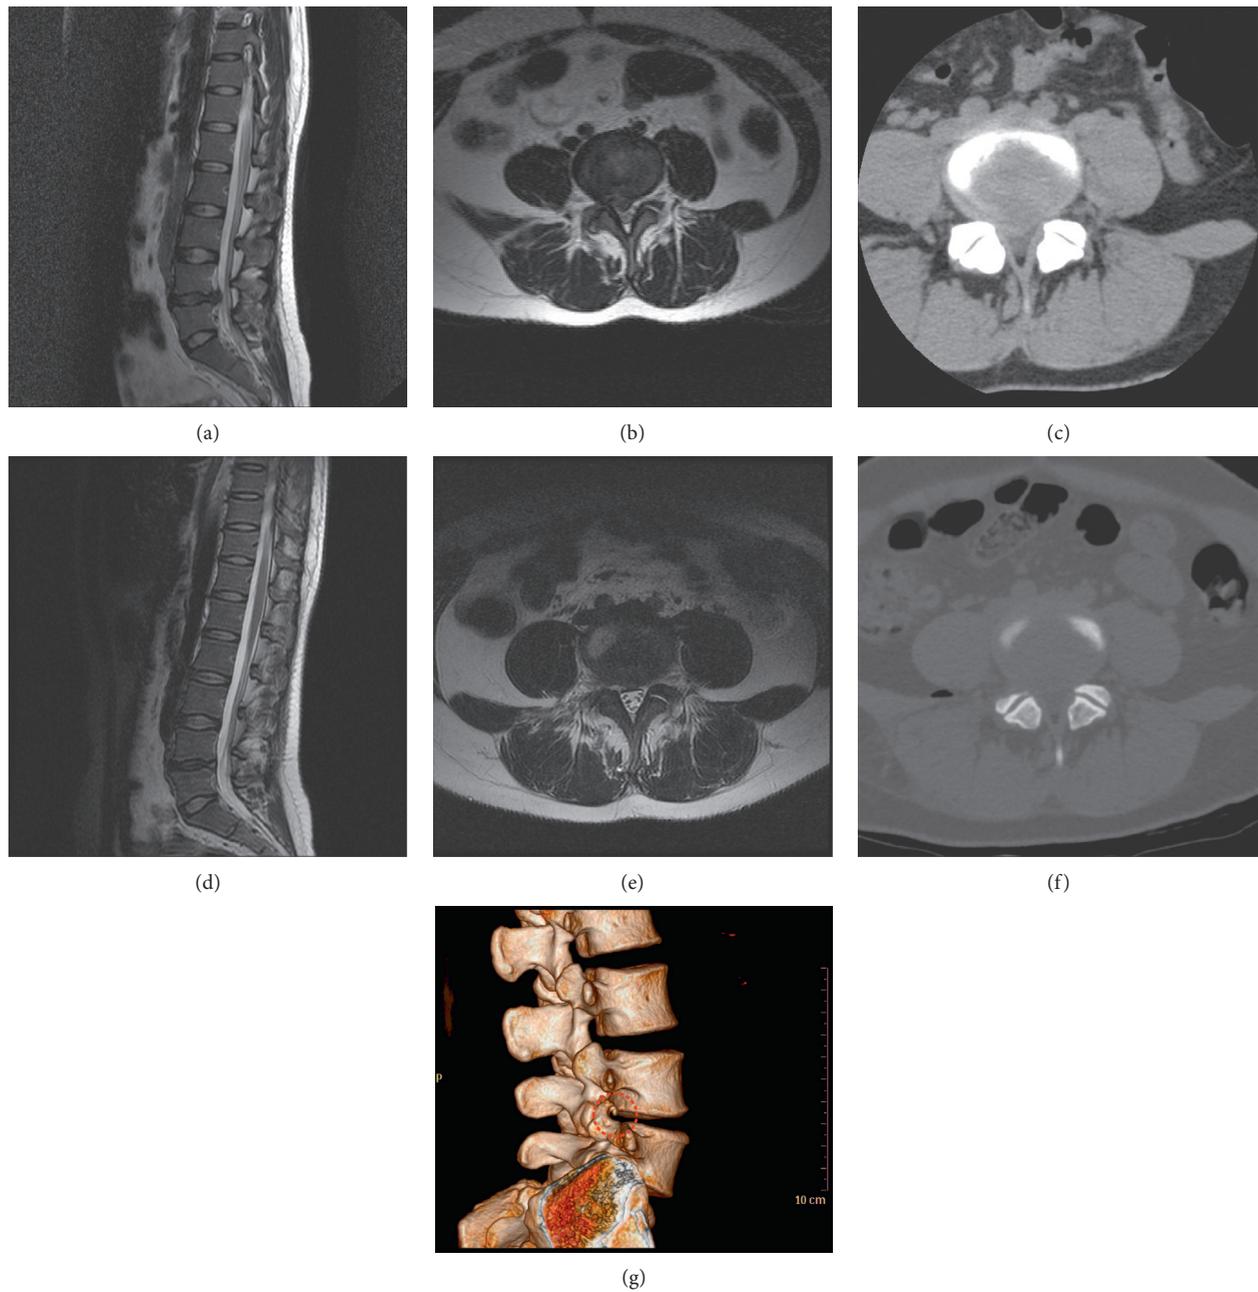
The preoperative and postoperative imaging data of patient who received TF PELF. (a and b) A preoperative MRI image shows the sagittal and coronal views of a patient diagnosed with LDH. (c) A preoperative CT image of the same patient. (d and e) The postoperative MRI sagittal and coronal views of the patient after TF PELF. (f) A postoperative CT image. (g) The postoperative 3D CT imaging result. The red round denotes foraminoplasty.
